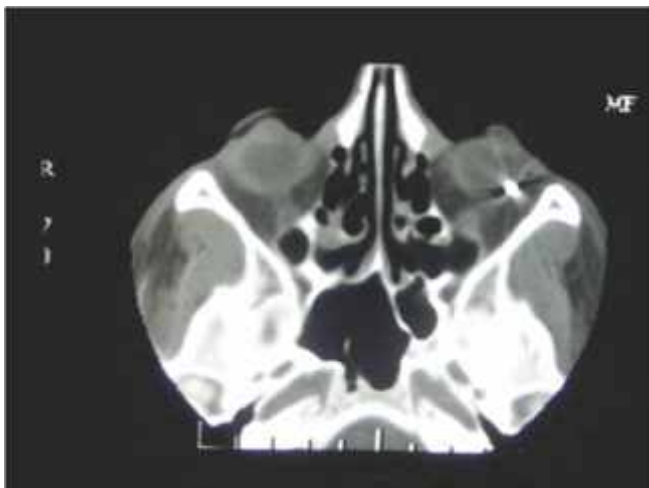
CT of foreign body in apex of orbit
